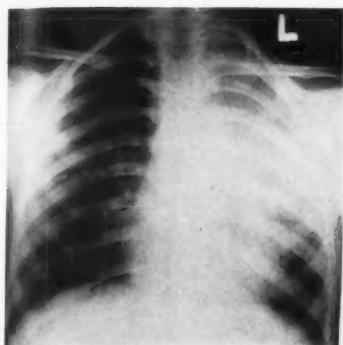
P.A. X-RAY 9/9/47. "EPI-TUBERCULOSIS." CASE 1. LEFT UPPER LOBE.
